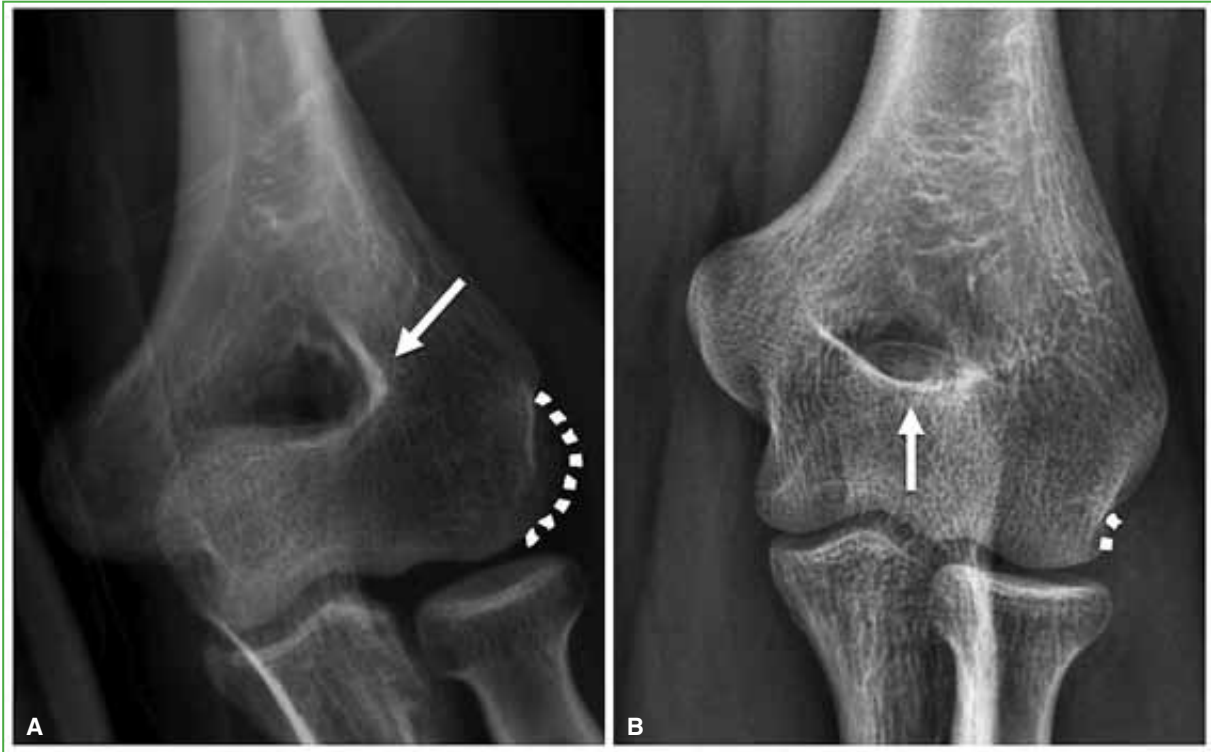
Radiological criteria. A. Anteroposterior radiograph of the distal humerus. The distal segment of the humerus is visualized with rotation according to anatomical retroversion. The arrow shows the sclerosis of the lateral border of the olecranon fossa. The asymmetry of the olecranon fossa can be appreciated. The dotted line shows the overprojection of the epicondyle over the capitellum of more than 50%. B. Anteroposterior radiograph of the distal humerus. The symmetry of the olecranon fossa is observed. The arrow indicates the sclerosis of the lower border of the olecranon fossa and the dotted line shows the absence of overprojection of the epicondyle over the capitellum.
